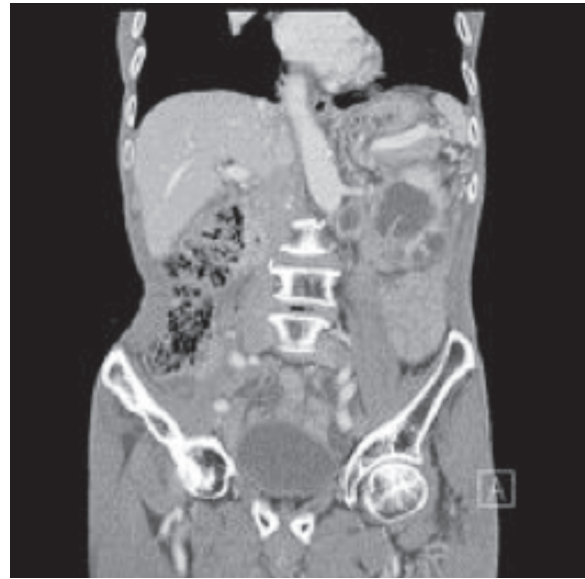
Later finding on computed tomography. CT scan revealed an 8.8-cm lobulated abscess with septation in the lower pole of the left kidney. No discrete masses were identified in the renal parenchyma.
